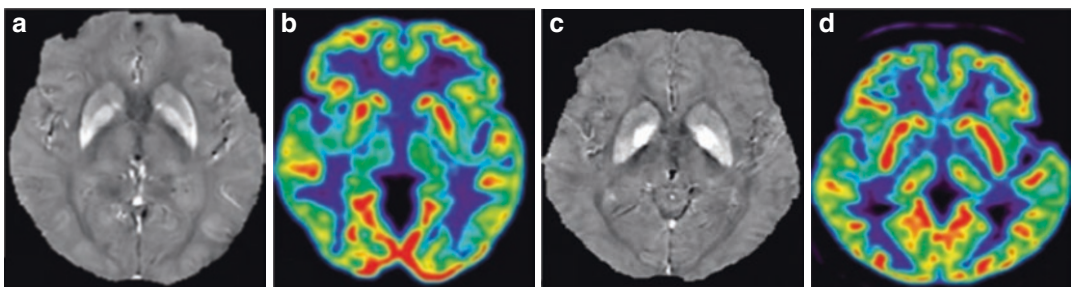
Integrated ^{18}F -FDG PET/MR of MSA-P and patients with PD. Transverse QSM imaging of MSA-P patient showing significantly increased iron deposition in the bilateral posterior putamen (a). Transverse ^{18}F -FDG PET imaging showing decreased ^{18}F -FDG uptake in the bilateral posterior putamen, which is more prominent on
